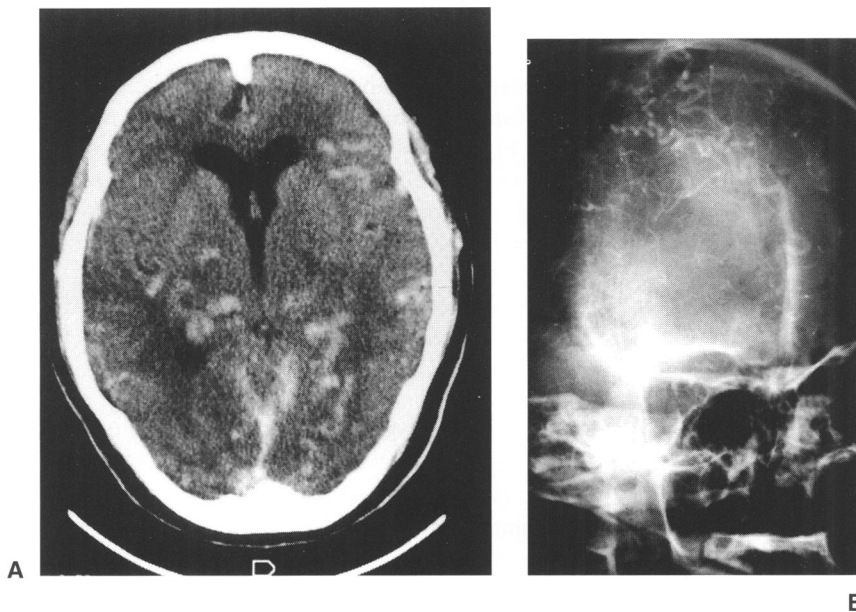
(A) Emergent CT showed diffuse brain edema and engorgement of cerebral veins. (B) Angiography revealed the occlusion of all SSS.
